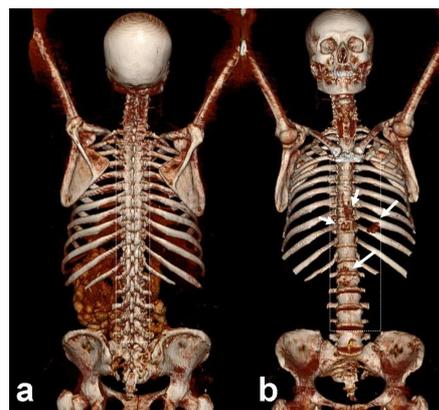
Involvement of the dorsolumbar spinal colon in a patient with non-Hodgkin lymphoma. a) Posterior aspect of the colon shows faint surface regularity and homogeneous colour pattern. b) But in anterior projection, the same case's 3D-colored, volume rendered CT image reveals the lytic, involved sites as confirmatory for malignant changes.
